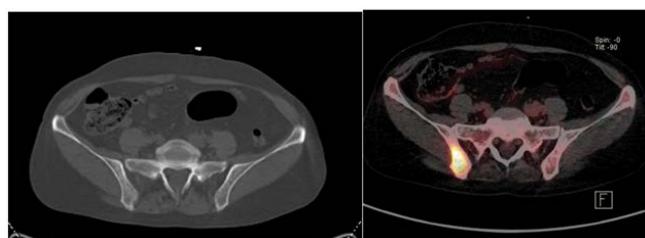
7: CT and PET images that show right iliac bone lesion with high radiotracer uptake only visible on PET.
